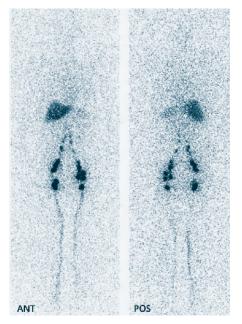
Normal 4h lymphoscintigram. Note the clear visualization of lymphatic channels, inguinal lymph nodes, and liver.
